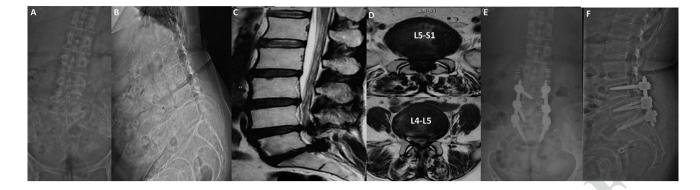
Example MI-TLIF in an obese female a, b: Preoperative radiographs of the lumbosacral spine in the anteroposterior a and lateral b views of the patient showing degenerative disease with loss of lumbar lordosis; c, d: Preoperative MRI of the lumbosacral spine showing
